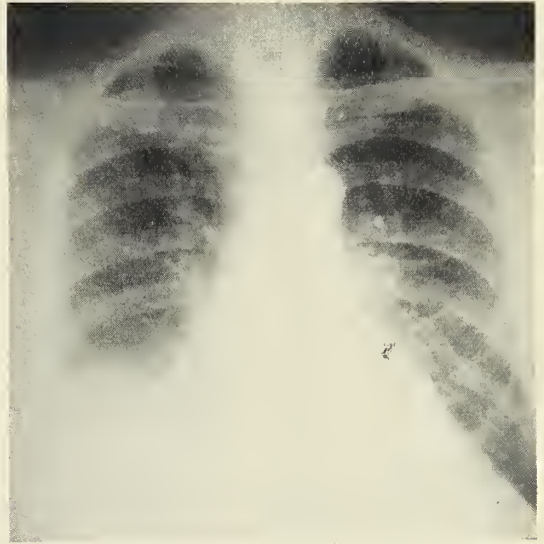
Roentgenogram of the lung at the time of admission to hospital. Note a small area of pneumonia and pleurisy, right base.
